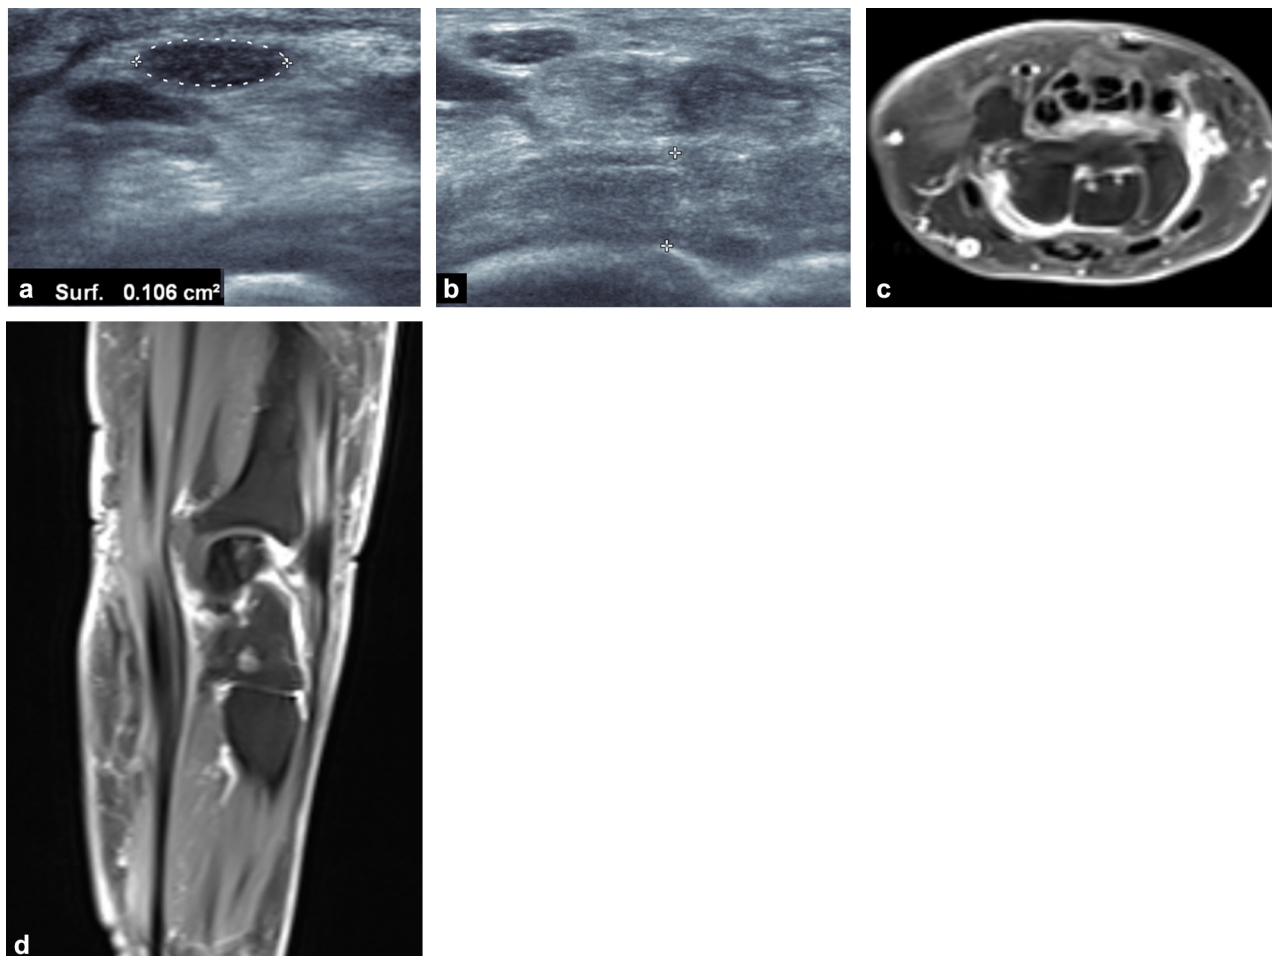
Clinical case: postoperative ultrasound and MRI. a, b: ultrasound images in the transverse plane; c, d: fat-saturated T1-weighted images in the (c) sagittal and (d) transverse planes obtained after intravenous administration of a gadolinium chelate.
